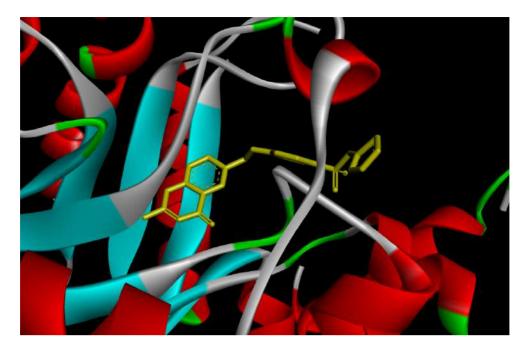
X-ray structure of WT DHPS in complex with STZ-DHP (PDB ID 6JWU)
